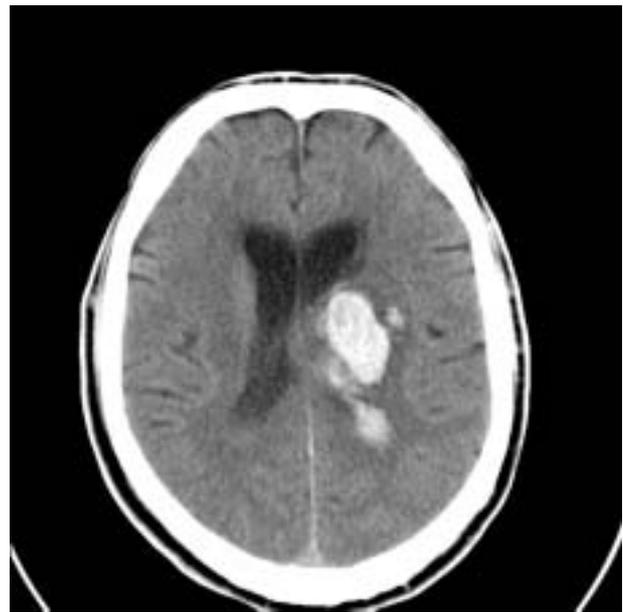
Computed tomography scan, showing a thalamic bleed with breakthrough to the ventricles, and blood in the posterior horns, 3rd and 4th ventricles, and aqueductus.
